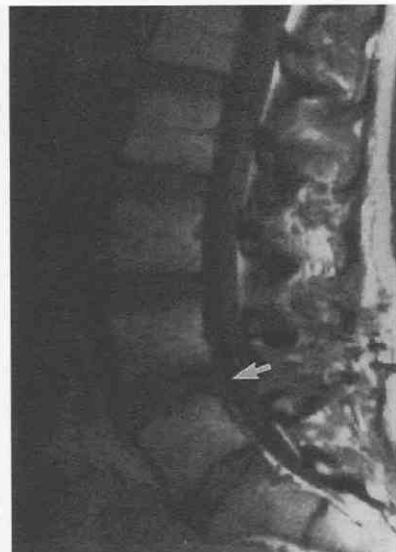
Sagittal T1-weighted postoperative MR image shows an apparent recurrent disk herniation (*arrow*) at L4-5. With contrast enhancement, this proved to be scar tissue.
